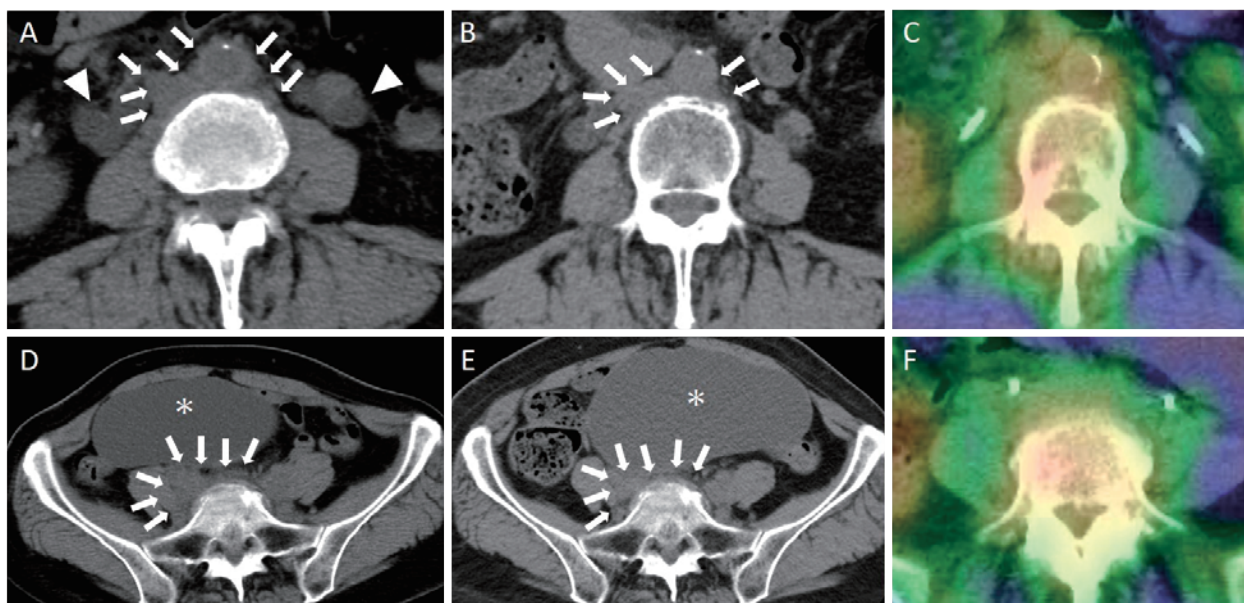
Serial plain computed tomography scan images of the presented case before (A and D) and after (B and E) treatment with corticosteroids and gallium scintigraphy images before treatment (C and F). A retroperitoneal mass and thickening of the outer layer of abdominal aorta wall improved after the treatment. However, the common iliac arteries within the mass were poorly visualized. Gallium scintigraphy showed mild uptake in the periaortic and retroperitoneal regions surrounding of abdominal aorta and bilateral common iliac arteries (arrow: retroperitoneal mass, arrow head: dilated ureter, asterisks: ovarian cyst).
